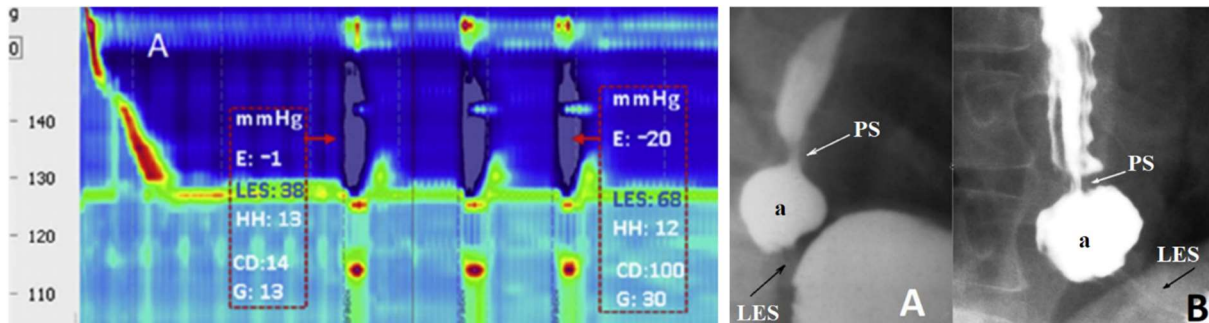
Manometric graph from the article of Mittal et al [25]. The two high-pressure zones (brown spots) do not have specific characteristics based on which anatomical affiliation could be accurately established. The length and extent of the upper zone are less than that of the lower one. A hiatus hernia (HH) is between them. Since there is no mixing of the LES, and what has considered HH is in fact the phrenic ampulla, the lower zone of high pressure is due to the contraction of the LES and the crural diaphragm (CD), and the upper zone is due to the contraction of the proximal sphincter (PS). (b) Radiographs of patients with GERD. (A) Child. (B) An elderly person. The designations are the same, [a] - ampulla.
